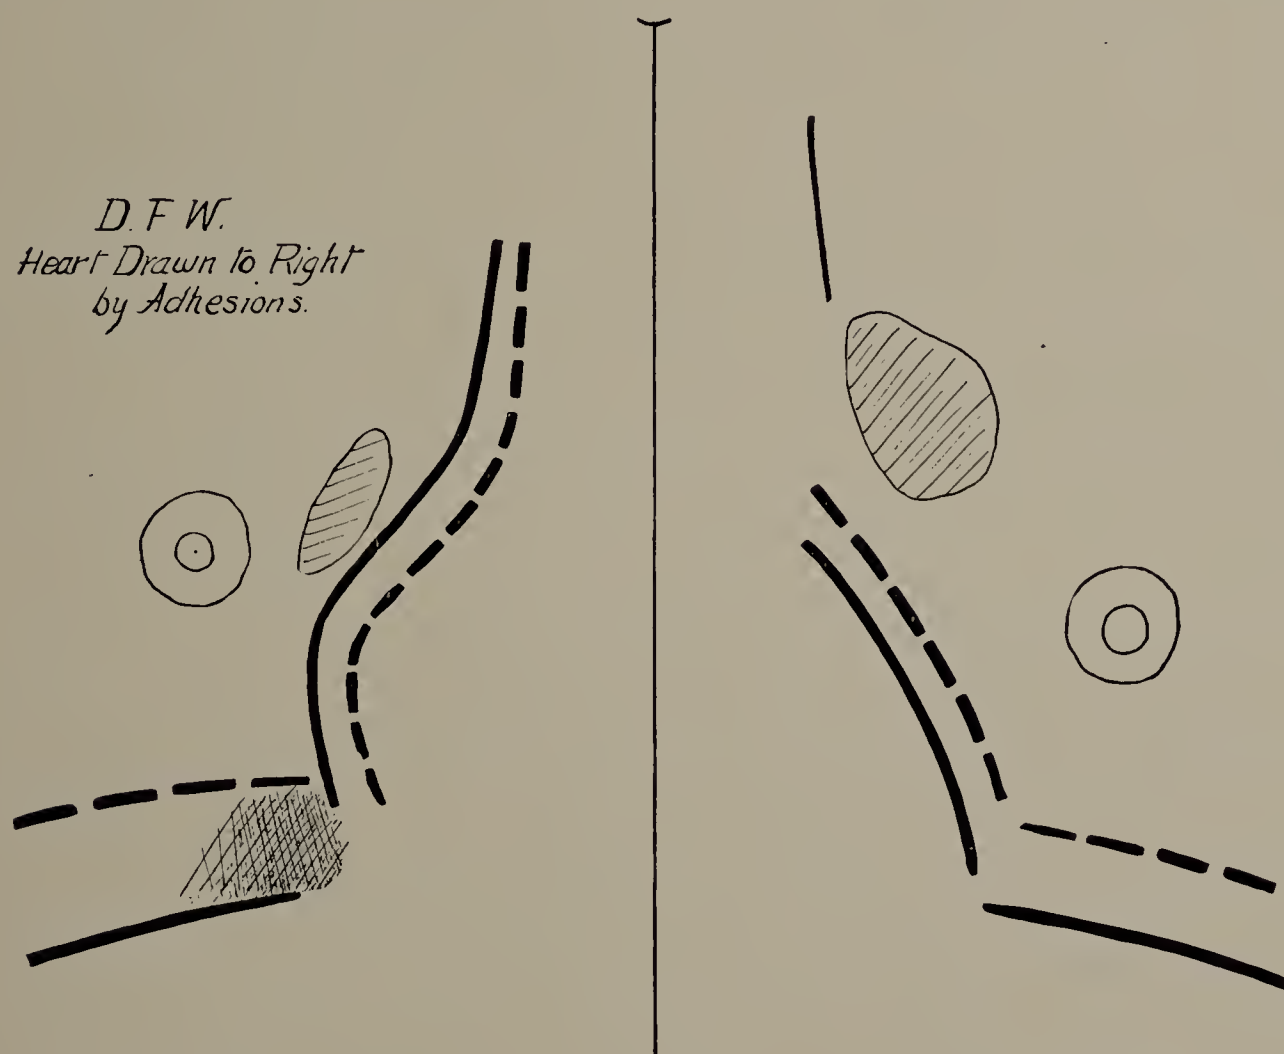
D. F. W. X-ray tracing (one-third life size). Heart drawn to the right. Full lines indicate the position of heart and diaphragm in full inspiration; broken lines in expiration. This movement is exceptional, as usually the right side of the heart in full inspiration would not move in this way.
